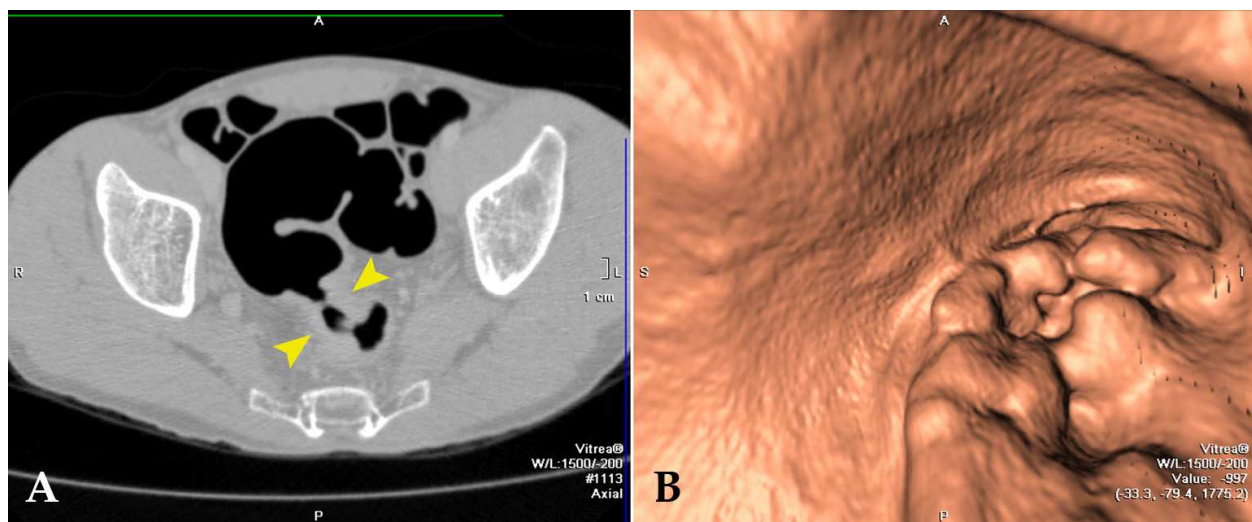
(A) 2D axial CT colonographic image shows circular wall thickening in the rectum (arrowheads). (B) 3D CT colonographic image shows an irregular, circular, stenotic filling defect.
